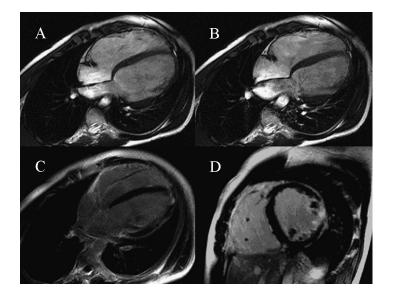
Diastolic (A) and systolic (B) cine MR images in the horizontal long axis orientation show severely enlarged, hypokinetic right ventricle in a 28-yr-old male patient (patient no. 4). The inversion-recovery turbo FLASH sequence shows contrast enhancement of the right (C, D) and the left ventricular wall (D).
